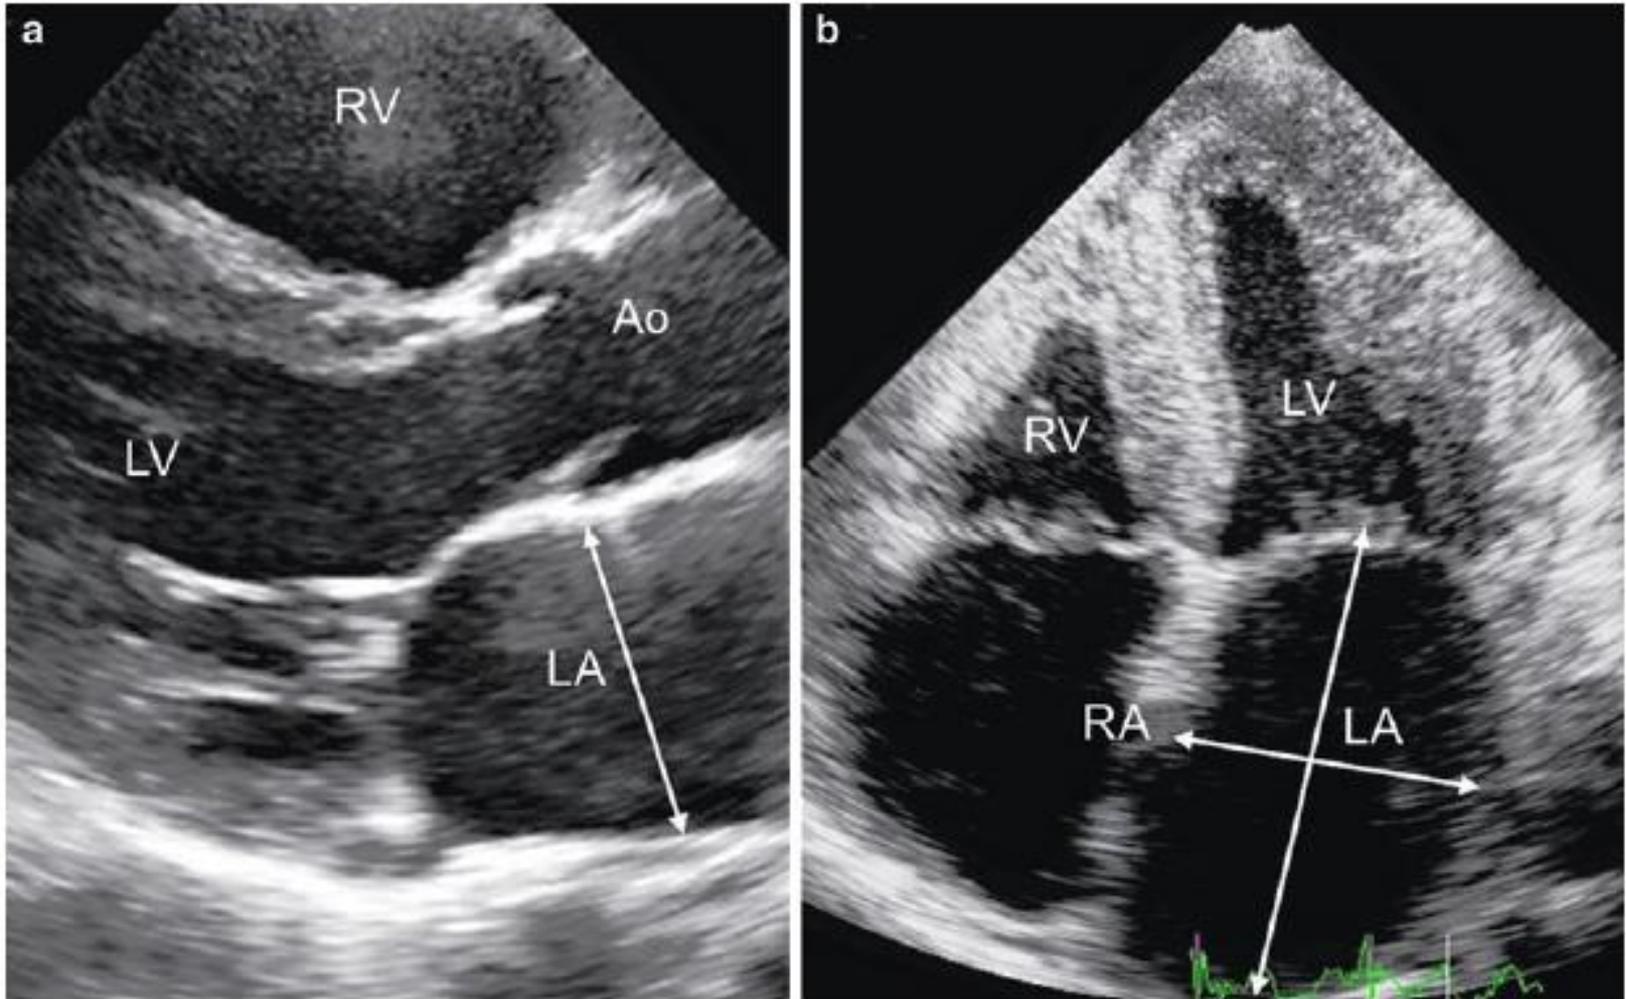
a Parasternal long-axis view and (b) apical four-chamber view with linear measurements of the left atrium. LA left atrium, LV left ventricle, RA right atrium, RV right ventricle, Ao aorta
